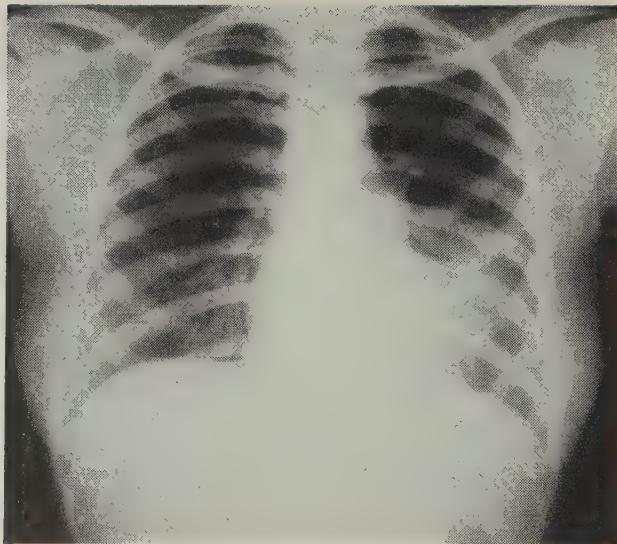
Lobar pneumonia, left lower lobe, is seen in this roentgenogram made on August 23, 1958. (Case E. D.)
